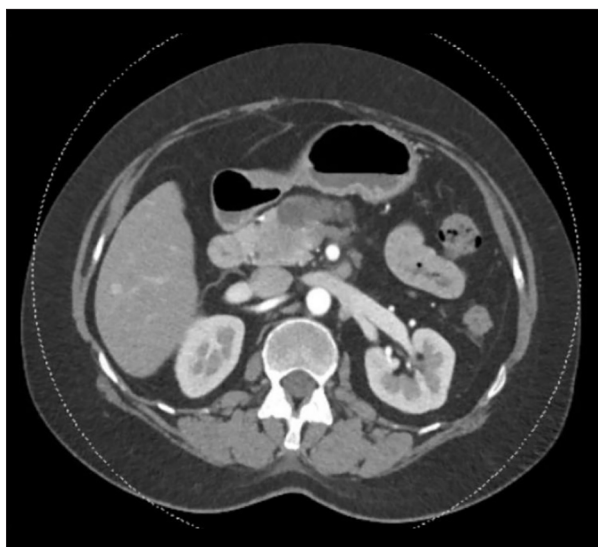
Axial view of a chest CT without contrast which revealed an ill-defined hypodense lesion in the region of the pancreatic head measuring up to 3.4 cm, concerning for malignancy. CT – computed tomography.
